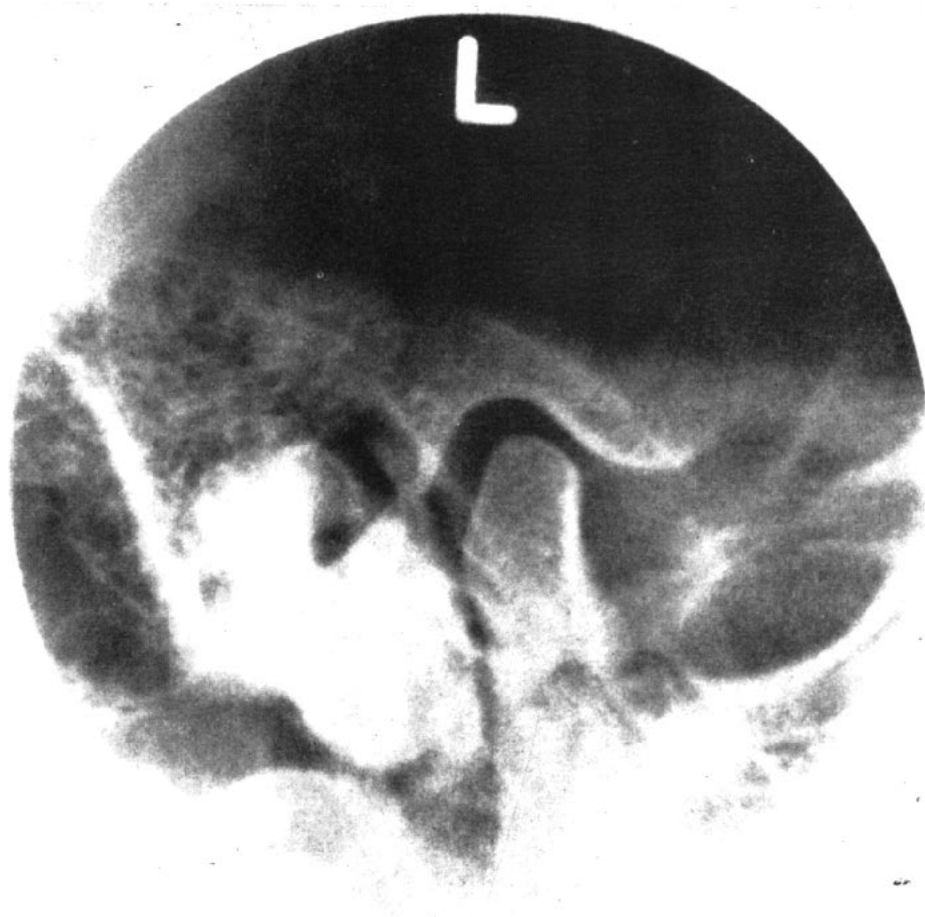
Lateral aspect radiograph of the temporomandibular joint.
